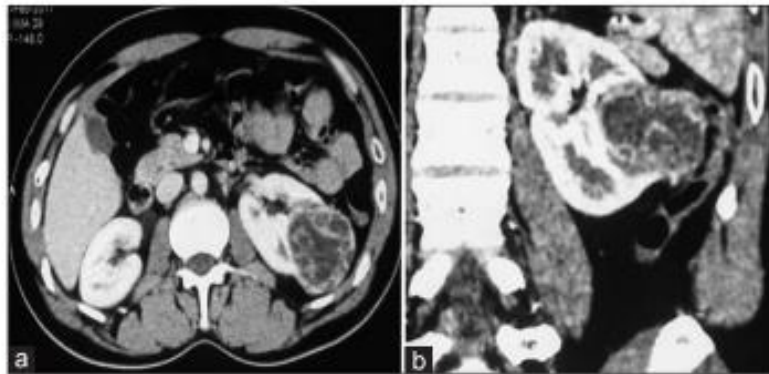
(a and b) Computed tomography scan shows a left-sided mid-polar mass of the size 5 cm×5cm.
